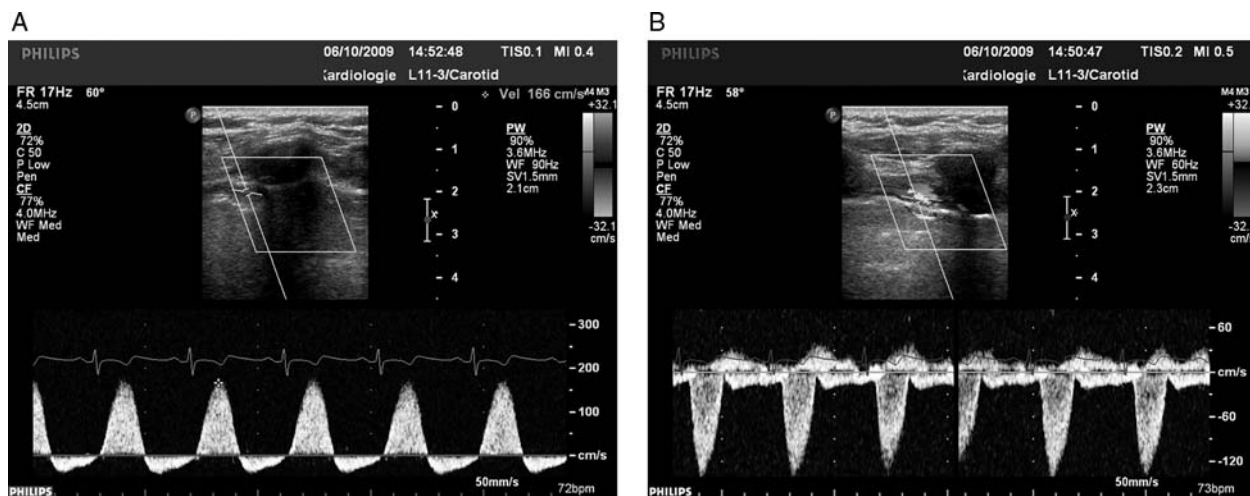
(A) Doppler ultrasound image of the proximal left mammary artery to left anterior descending artery graft prior left subclavian artery angioplasty; systolic reversal flow and mild diastolic orthograde flow is present. (B) Doppler ultrasound image of the proximal right mammary artery; normal arterial orthograde waveform contrasting with the opposite systolic direction of the flow in LIMA–LAD graft in (A).
